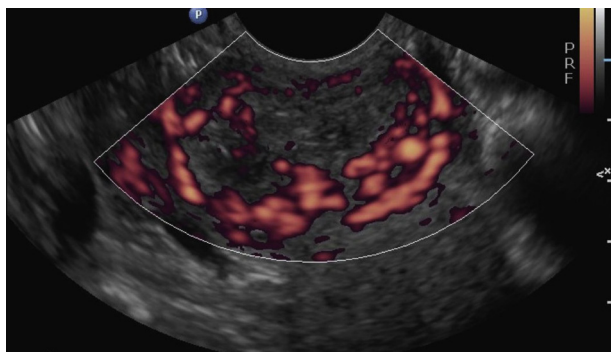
Case 4. Color Doppler showing increased hypervascularity of the heterogeneous mass in the region of the scar ectopic pregnancy. The patient subsequently underwent hysteroscopic and laparoscopic-guided suction curettage as secondary treatment.
